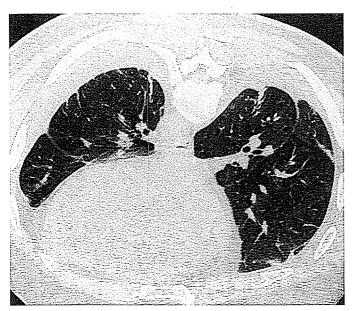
Cryptogenic bilateral fibrosing pleuritis. Prone CT image shows bilateral smooth pleural thickening with bilateral lower lobe volume loss and parenchymal scarring.
